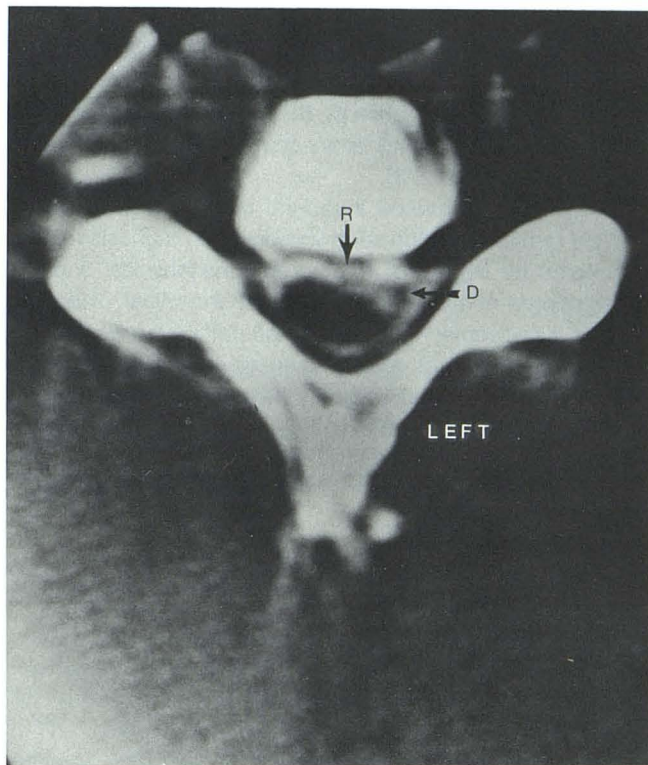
Metrizamide CT scan at C5-C6 interspace with intradural disk fragment (D). Note the irregularity of the ventral dural sac with metrizamide within the dural sac between the disk fragment (D) and the displaced spinal cord. The metrizamide apparently entered the dural sac through rupture site (R).
